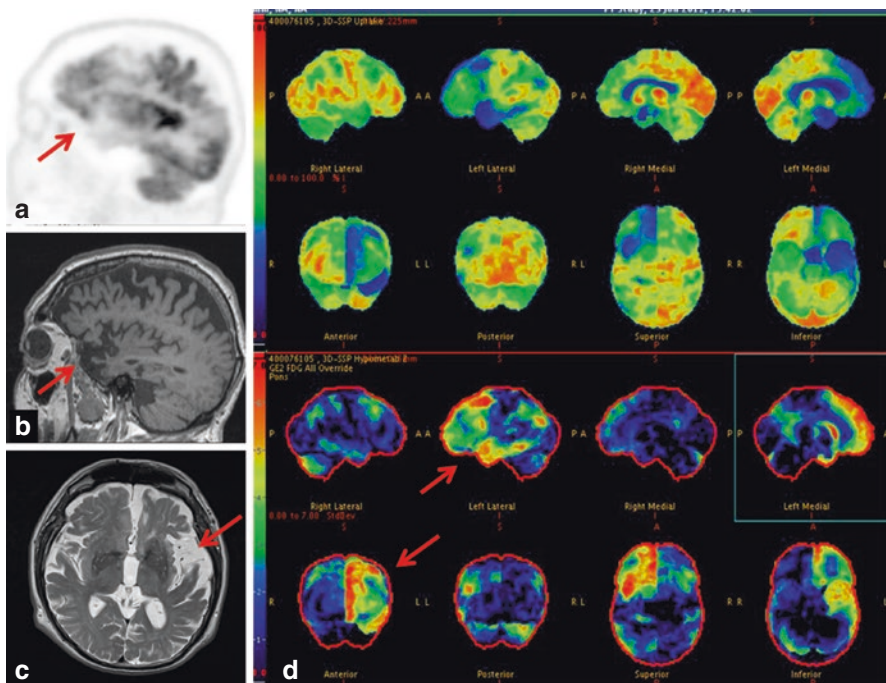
(a–d) Sagittal ^{18}F FDG PET (a), sagittal T1WI (b), axial T2WI (c) and Z-score maps (d) show reduced FDG uptake in the left frontotemporal lobe (a, arrow) corresponding to cerebral atrophy on MRI (b, c arrows) and confirmed on quantification assessment (d, arrows), in keeping with frontotemporal dementia.
